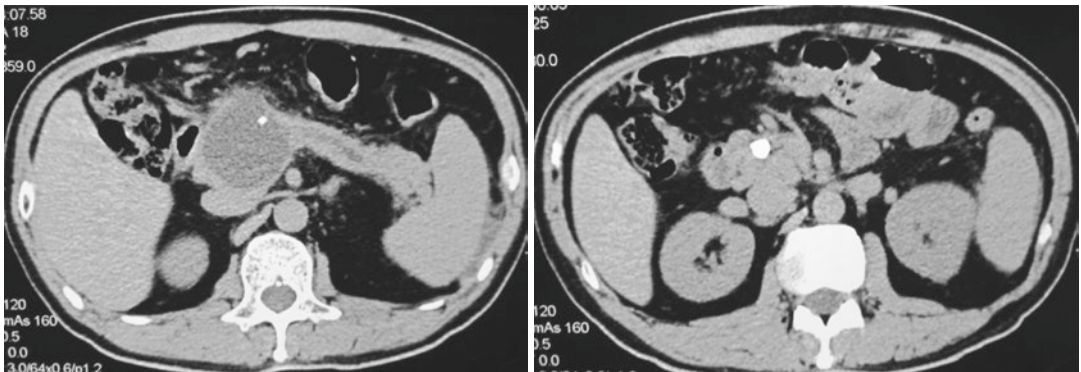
CT revealed atrophy in the pancreatic body and tail, bead-like dilatation of the main pancreatic duct, a cystic density lesion with clearly defined margins measuring 5.6 * 4.7 cm in the pancreatic neck, nodular and punctate high-density shadows in the pancreatic head and body, and peripancreatic fluid collections
